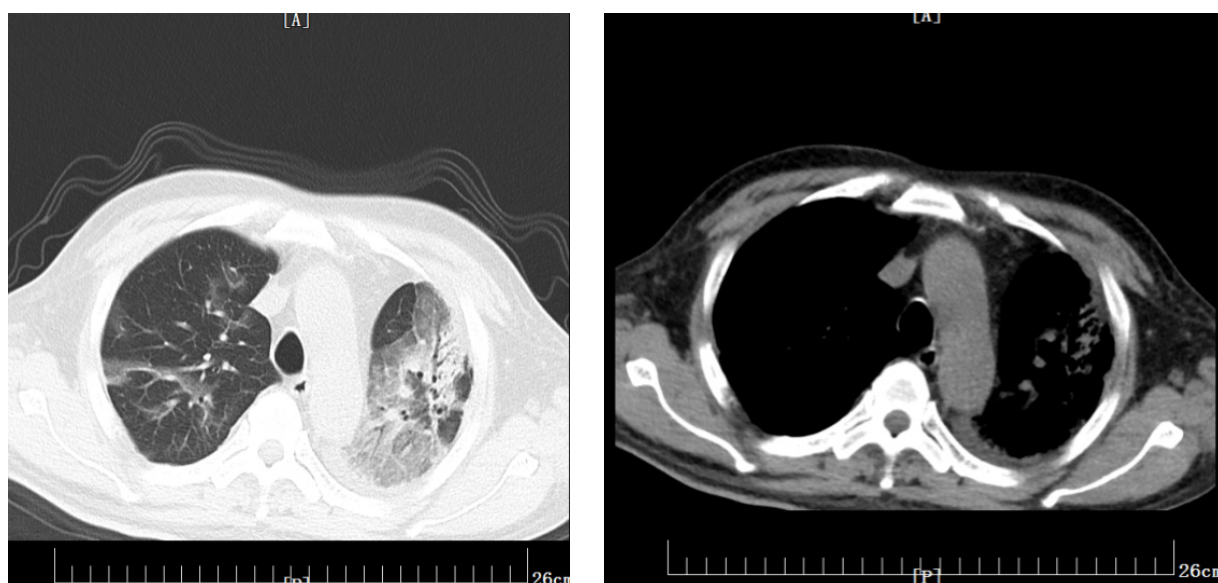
Repeat chest CT. (Left) Lung window: increased consolidation and ground-glass opacities in the upper lobe of the left lung; (Right) Mediastinal window: increased consolidation
